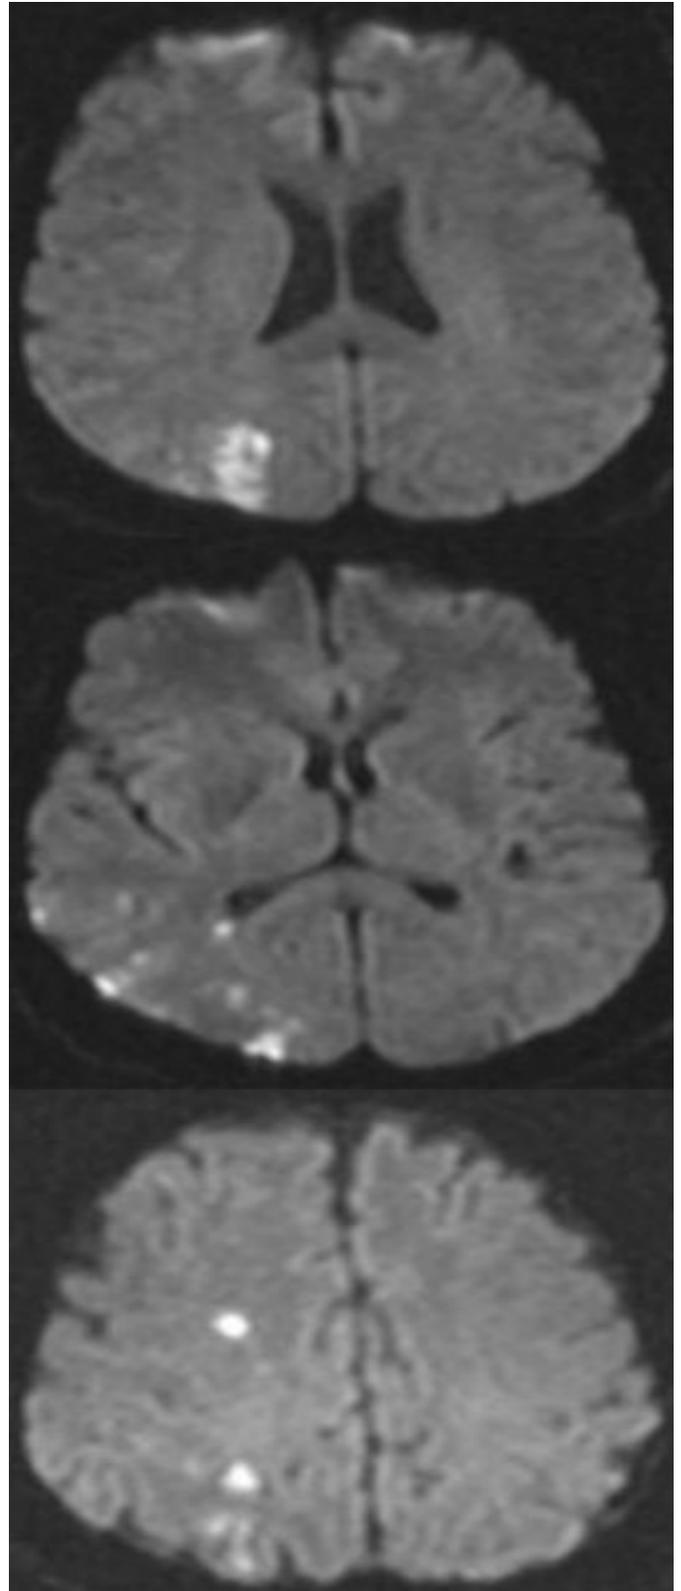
Diffusion-Weighted Image (DWI) axial sections are demonstrating restriction of diffusion in the posterior circulation as well as the MCA watershed territory.
